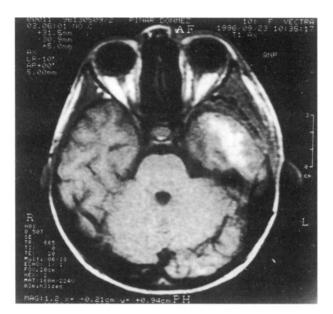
Note the blood in the trajectory of the spearhead on MRI.
